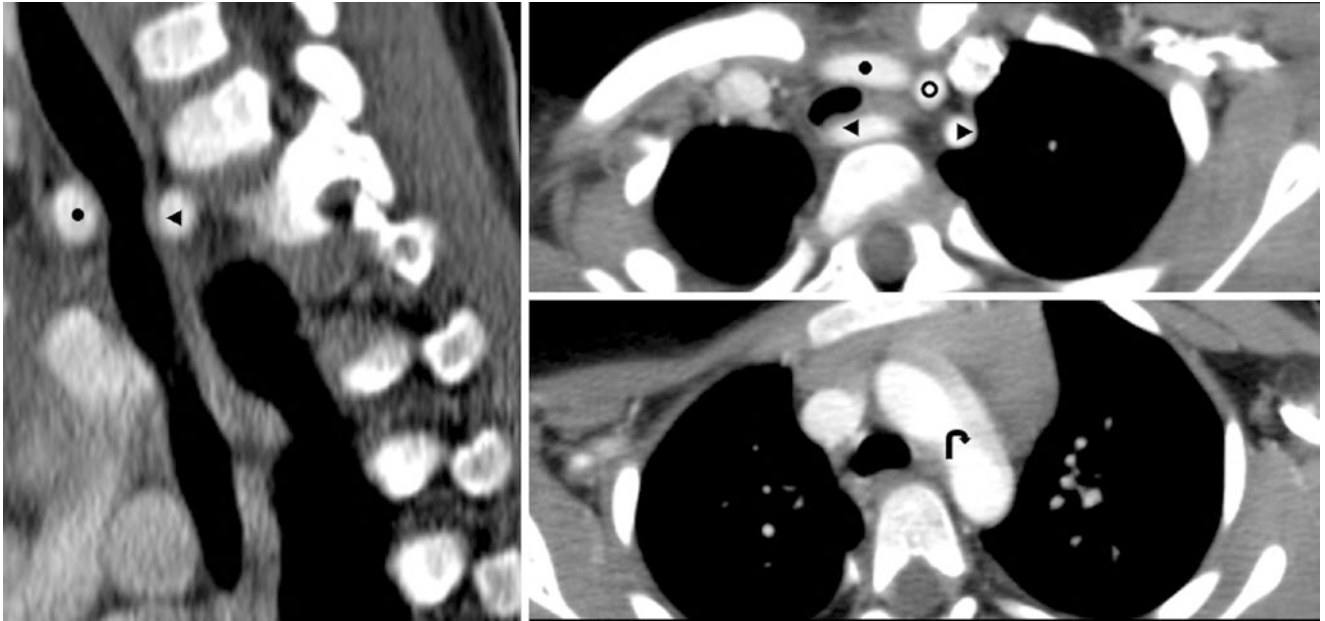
In a 3-year-old, a sagittal postcontrast thoracic spine CT (*left*) demonstrates a left-sided aortic arch with a retroesophageal RSCA. Axial images from a chest CT (*right, top and bottom*) confirmed this finding. *Aortic Arch* (curved arrows); *IA* Innominate Artery (+);
